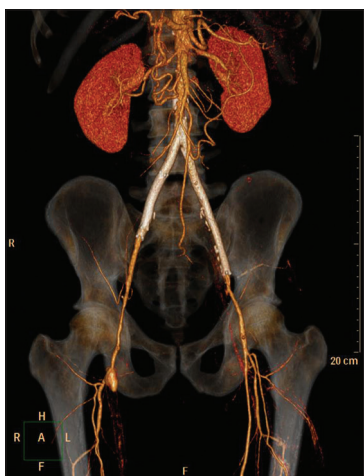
Computed tomography peripheral angiogram shows patent stent seen in relation to distal aorta, left common iliac artery, external right common iliac artery
